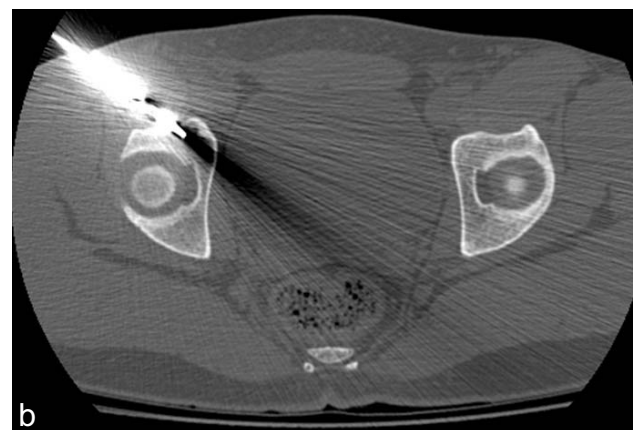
(a): CT-scan. Osteoid osteoma in right anterior acetabulum. We see the nidus with central calcification and skin marker for CT guidance. (b) MWA guide wire passed into the osteoid osteoma nidus.
